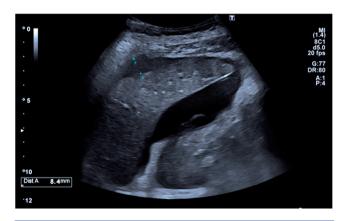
The abdominal ultrasound shows the presence of a voluminous perihepatic fluid collection.
